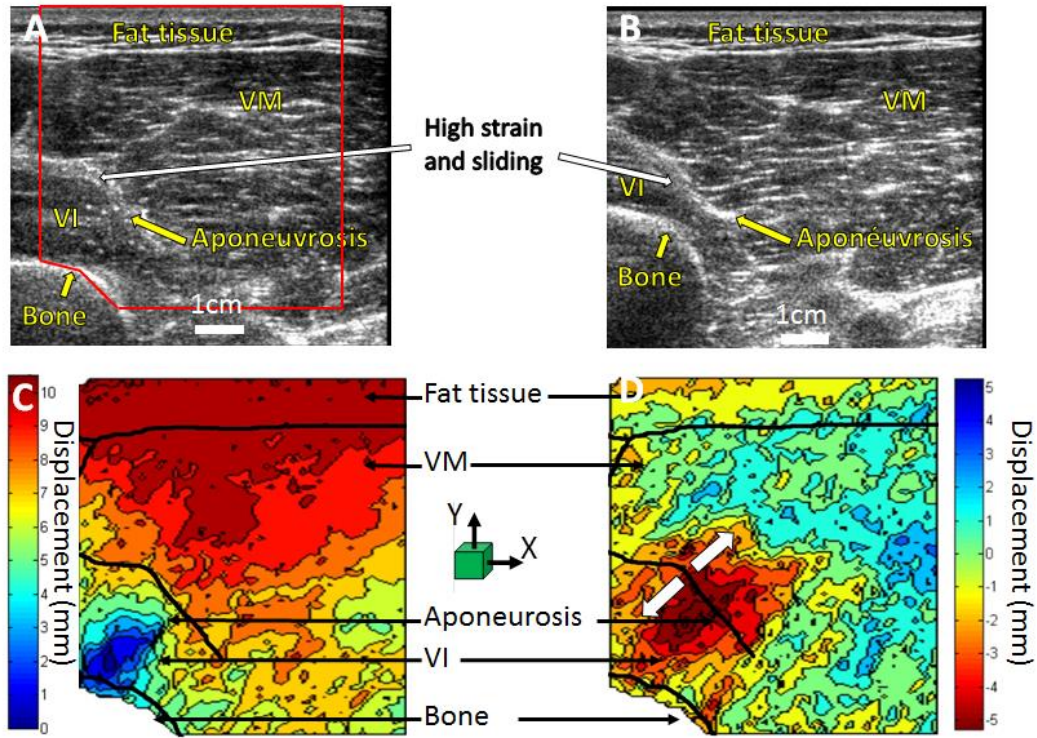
Ultrasound images of uncompressed (a) and compressed (b) quadriceps muscles composed of the Vastus Intermedius (VI) and the Vastus Medialis (VM). Cartographies of the displacement fields obtained along the axial (c) and lateral (d) axis
